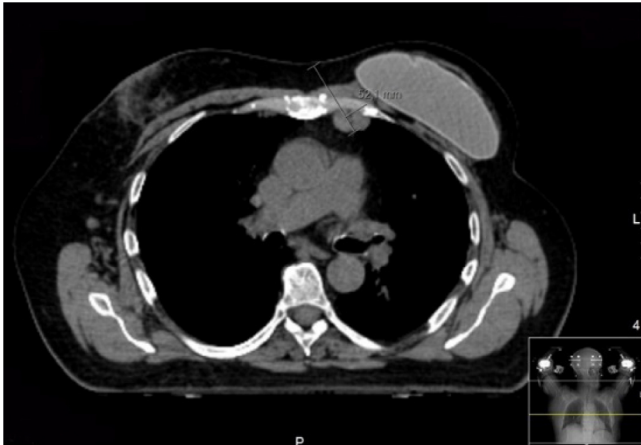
Planning computed tomography scan prior to radiotherapy (coronal plan): lymphadenopathy of the internal mammary lymph nodes on the left side.
